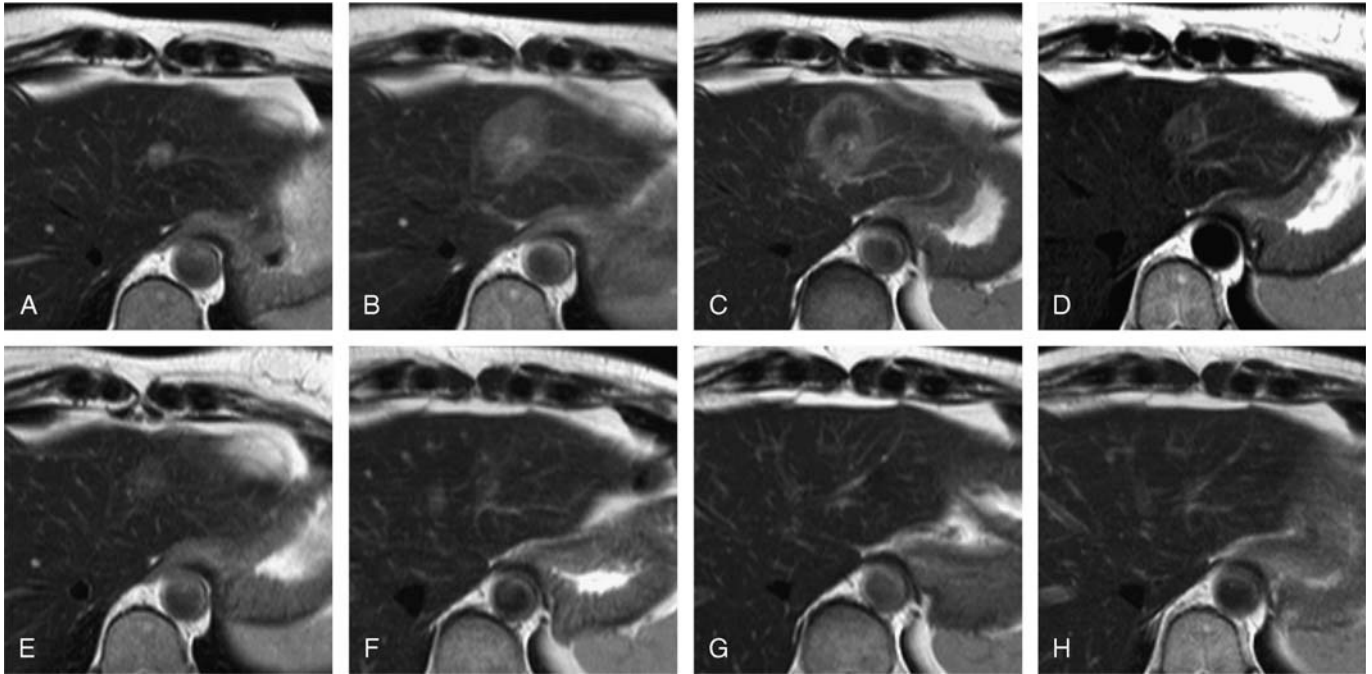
MRI patterns after IRE—T2w TSE. A 52-year-old female patient with metastatic breast cancer with a solitary metastasis in the left liver lobe located immediately adjacent to the main portal vein branch. Appearance of the target lesion and the IRE ablation zone on axial T2w TSE sequences at different time points: before ablation (A), 2 hours after IRE (B), and 24 hours after IRE (C), 1 week after IRE (D), 4 weeks after IRE (E), 8 weeks after IRE (F), 6 months after IRE (G), and 12 months after IRE (H). The target lesion was visible as a T2w hyperintense lesion (A). Immediately after IRE (2 hours) the ablation zone was visible as homogenously intermediately hyperintense area (B). One day after IRE, the SI of the ablation zone on T2w imaging inverted to become intermediately hypointense compared with normal liver parenchyma and exhibited a hyperintense rim that was observable around the entirety of the ablation zone (C). The ablation zone remained intermediately hypointense on T2w images, with a hyperintense rim 1 week (D) until 4 weeks (E) after ablation. The ablation area decreased continuously in size starting as early as 1 week after IRE (C) and finally disappeared completely (G and H).
